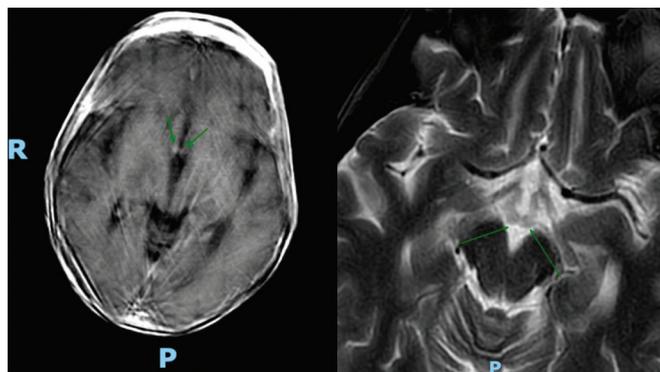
MRI. T2/FLAIR images showed alteration of midbrain tegmentum (posterior periaqueductal region, right), and mesial thalamic nuclei and anterior columns of the fornix (left), compatible with the diagnosis Wernicke Encephalopathy.
